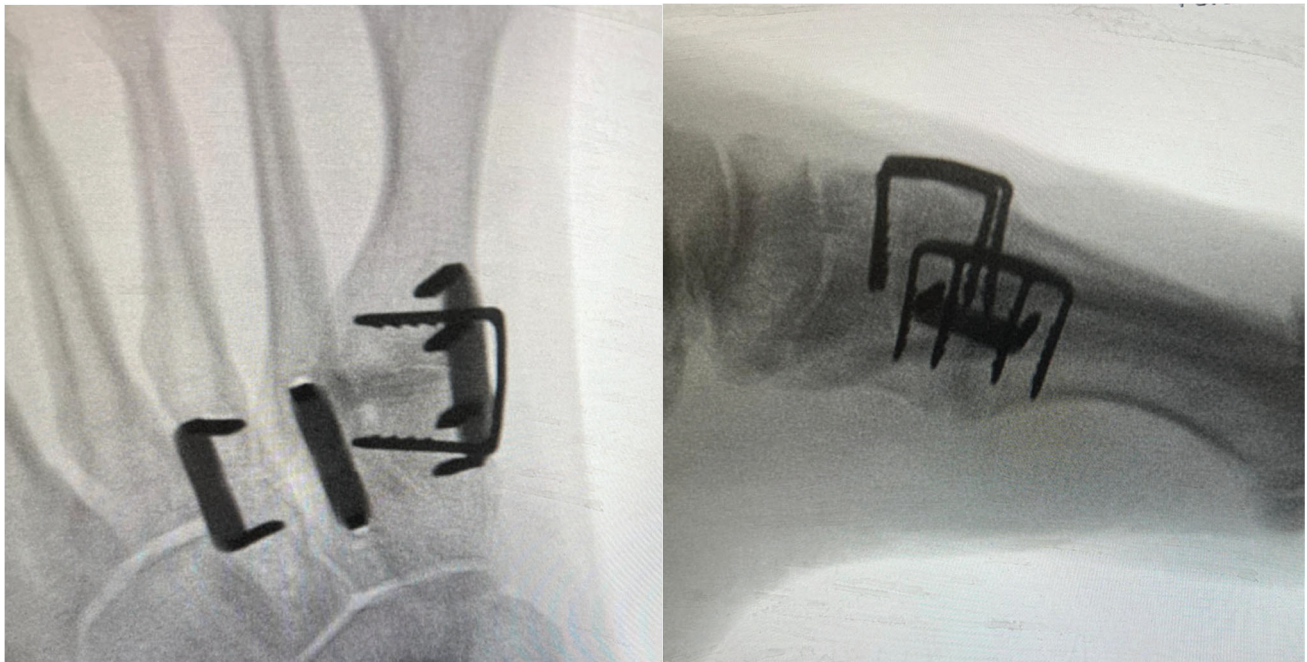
Intra-operative radiographs depicting fusion of tarsometatarsal joints with a combination of two- and four-leg staples.
